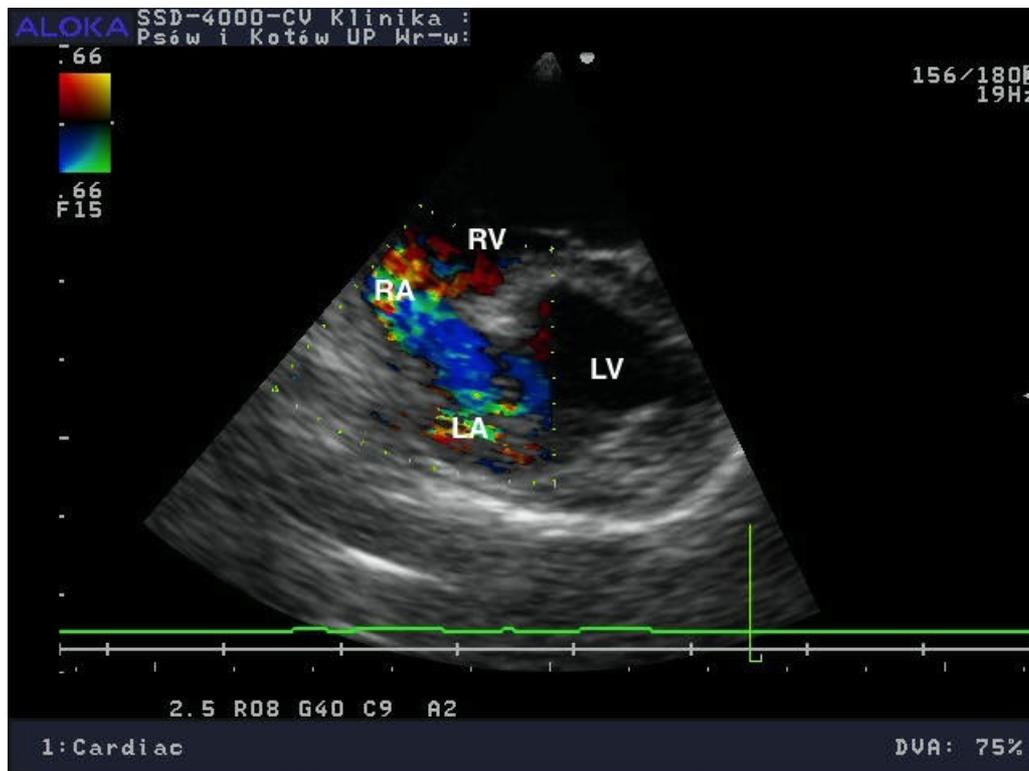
Color-flow Doppler echocardiogram. The right parasternal long axis four-chamber view (modified). The aliased signal indices turbulent flow in the enlarged atria. RA – Right atrium, LA – Left atrium, RV – Right ventricle, LV – Left ventricle.
